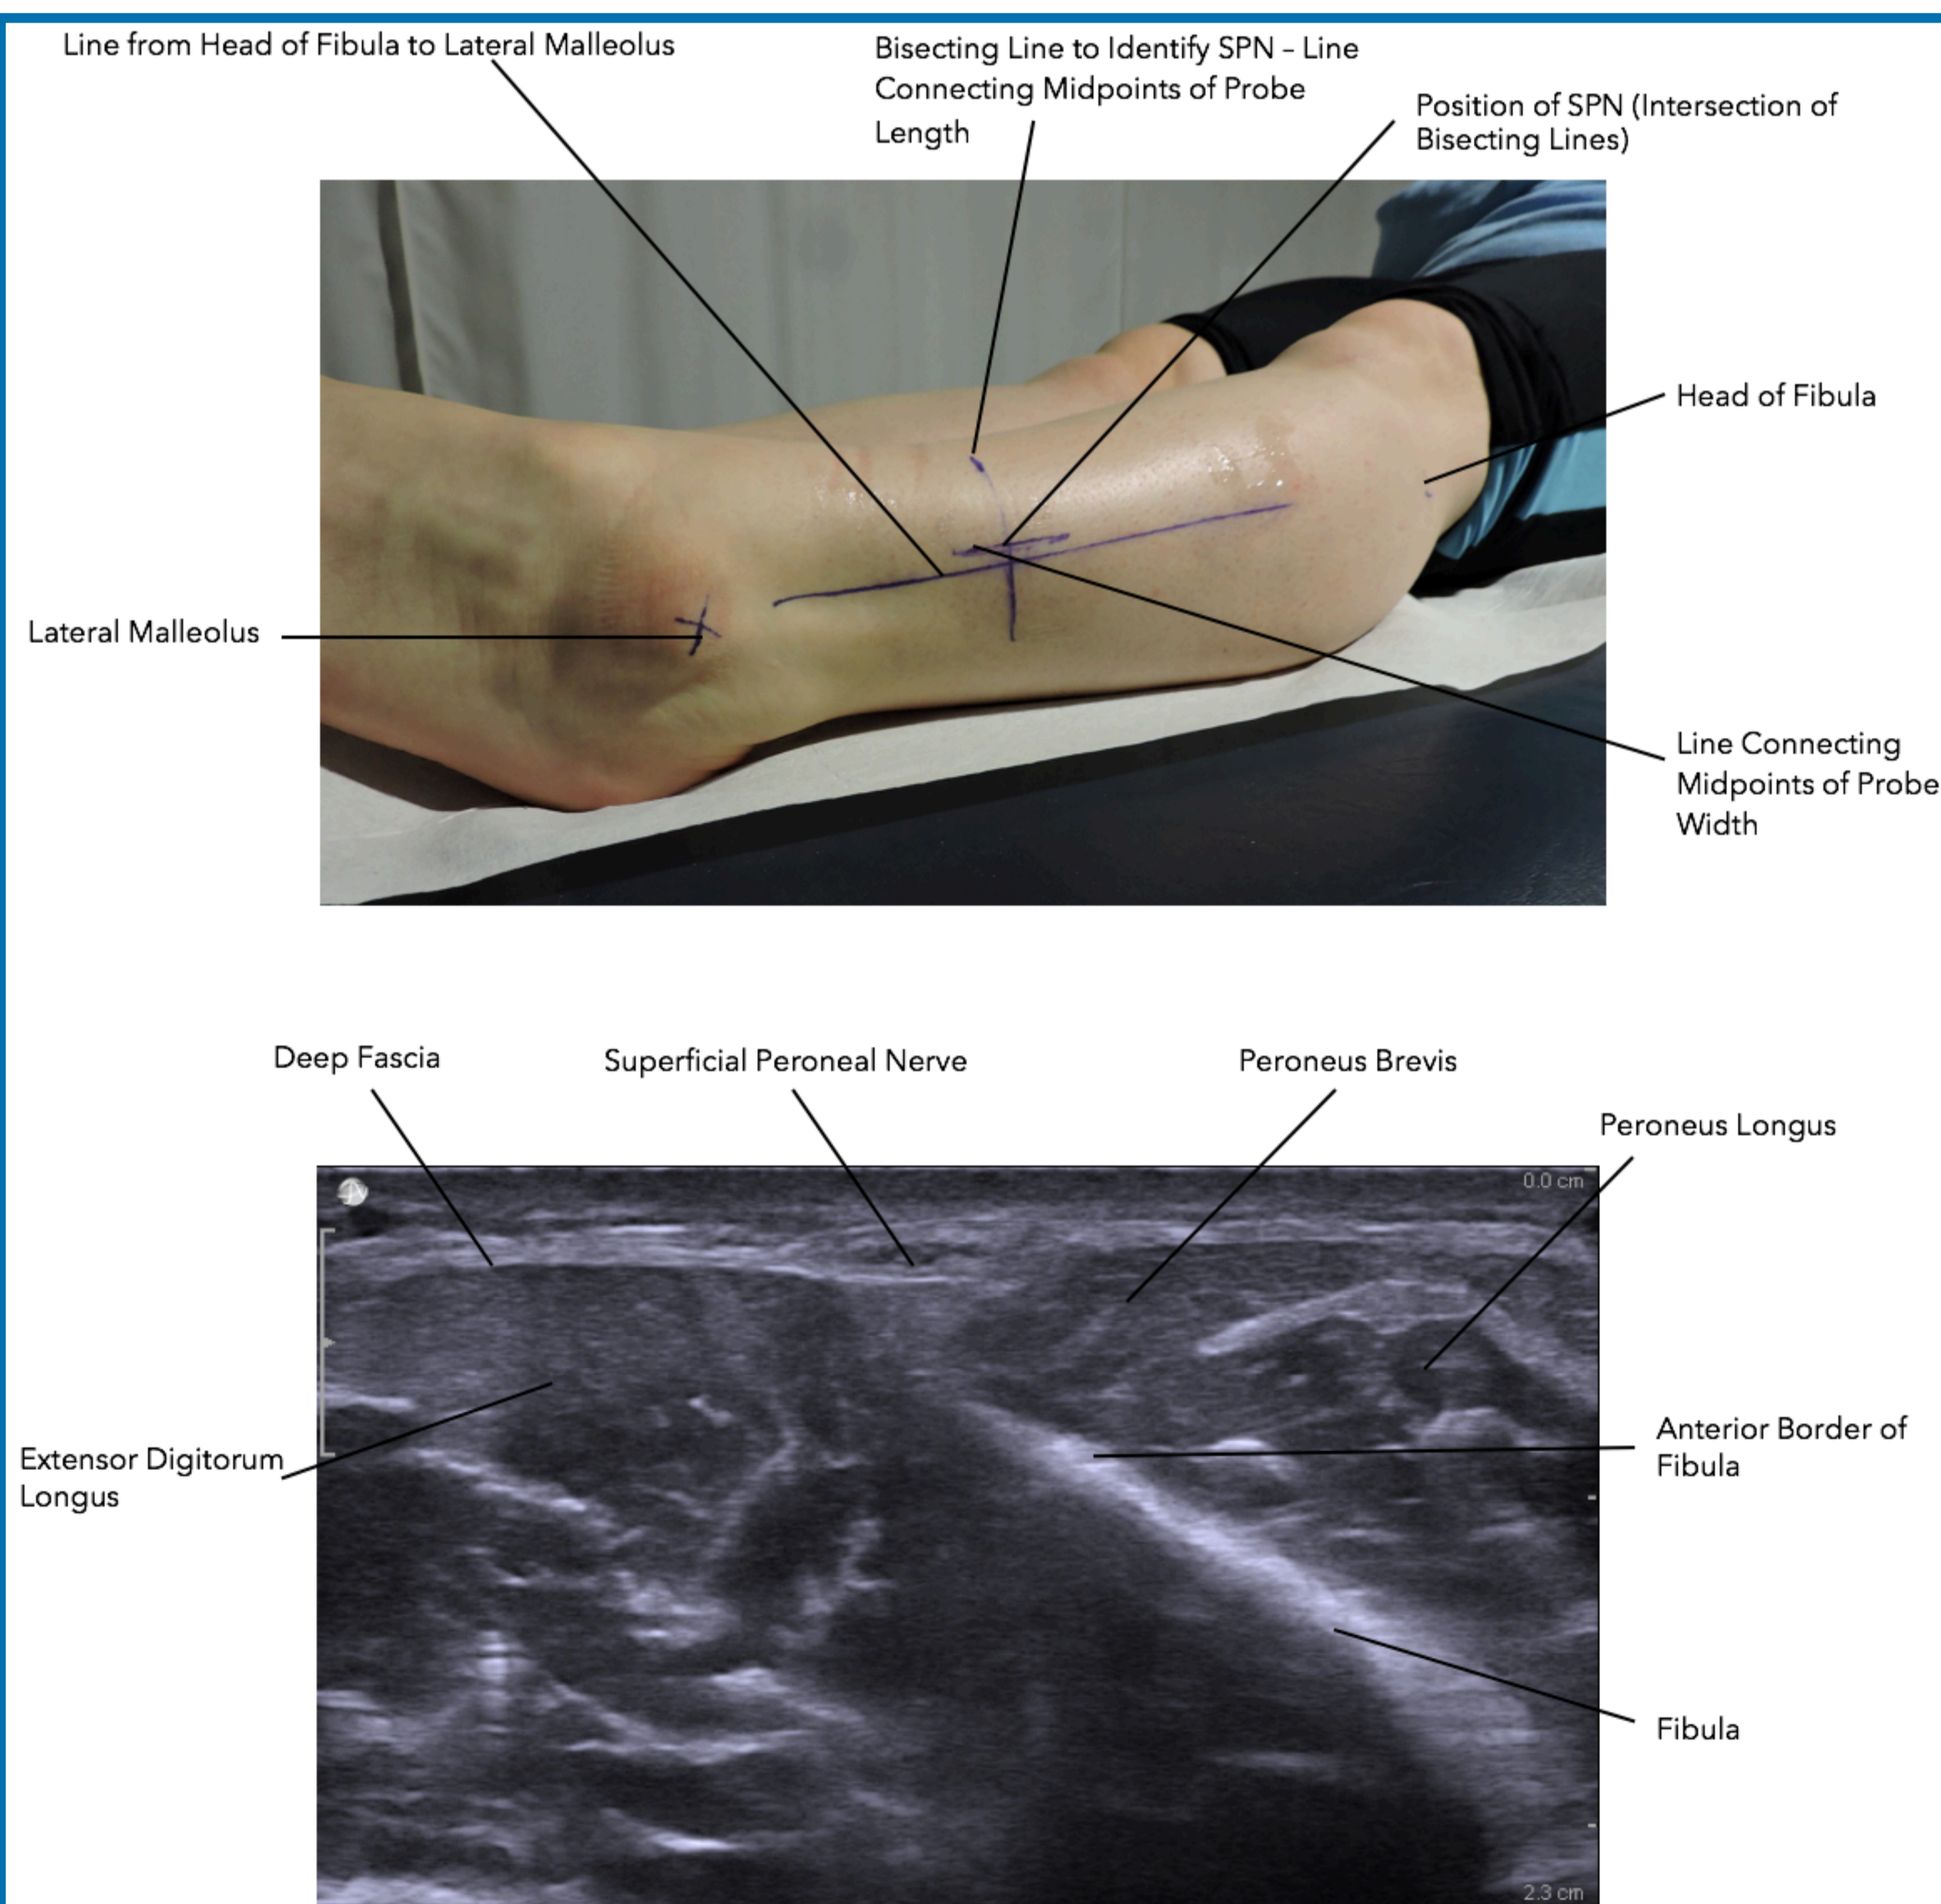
Markings drawn on an individual's leg and a sonographic picture of the SPN superficial to the deep fascia.
